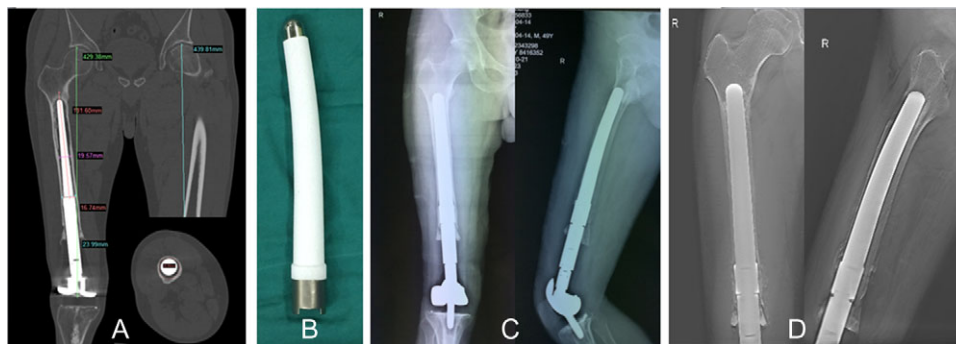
The prosthesis design and the radiographs of Patient 5 after the revision surgery. (A) The 3D precise design of the prosthesis based on the Mimics 3D images; (B) the prosthesis with titanium and hydroxyapatite coating; (C) the immediately postoperative anteroposterior and lateral radiographs; (D) the T-SMART images immediately after the revision surgery.
